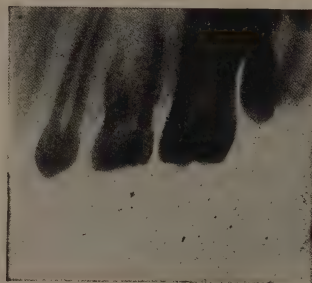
X-ray of Fig. 608—left side.
